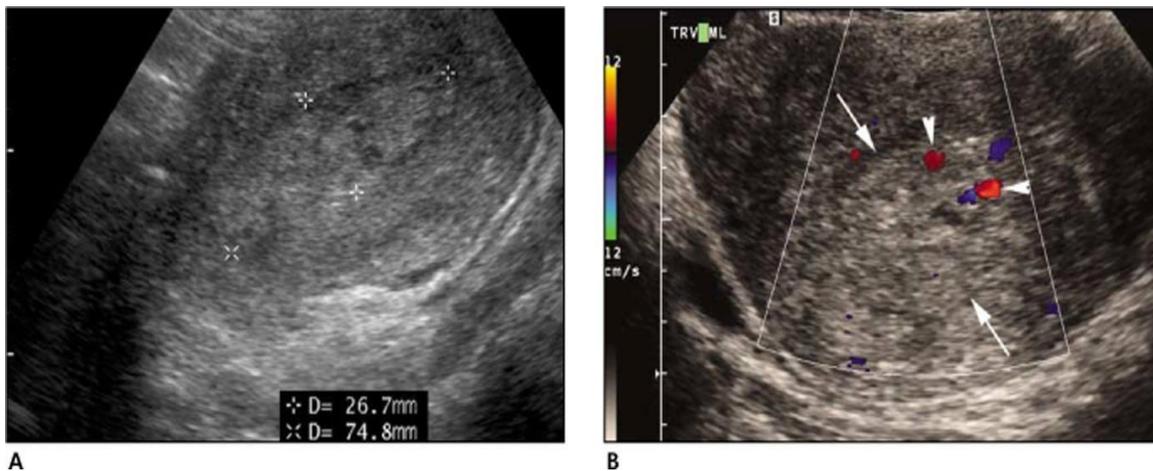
The Sonographic and Color Doppler Features of Retained Products of Conception.
